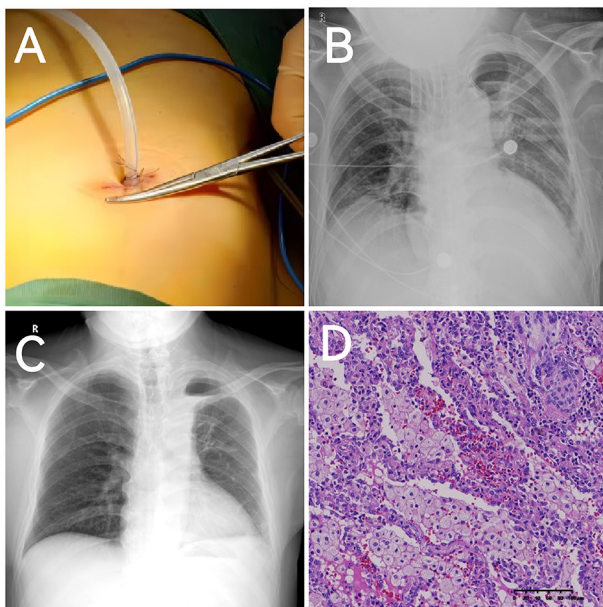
Surgical approach, chest radiography and postoperative pathology images. (A) Image showing the location of the single-port surgical incision, approximately 3 cm in length, and placement of the #19 drainage tube. (B) Chest X-ray at 2 h after surgery revealing no significant hydropneumothorax in the left thoracic cavity. (C) Good re-expansion of the left lung and only a small residual cavity at the top of the left thoracic cavity is observed at 3 weeks after surgery. (D) Image corresponding to the pathological examination of the lung lesion revealing pulmonary fibrous hyperplasia, with massive neutrophil and plasma cell infiltration, and massive foam cell accumulation in the alveolar space (magnification, x200).
